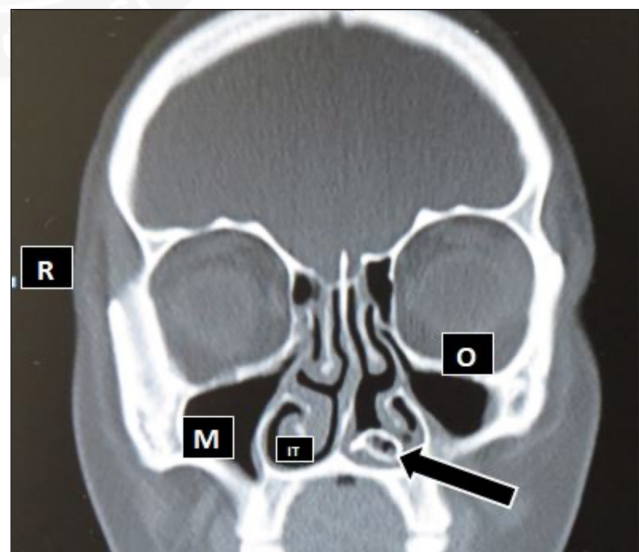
Computed tomography appearance of a rhinolith between the inferior turbinate and the septum on the left side.
